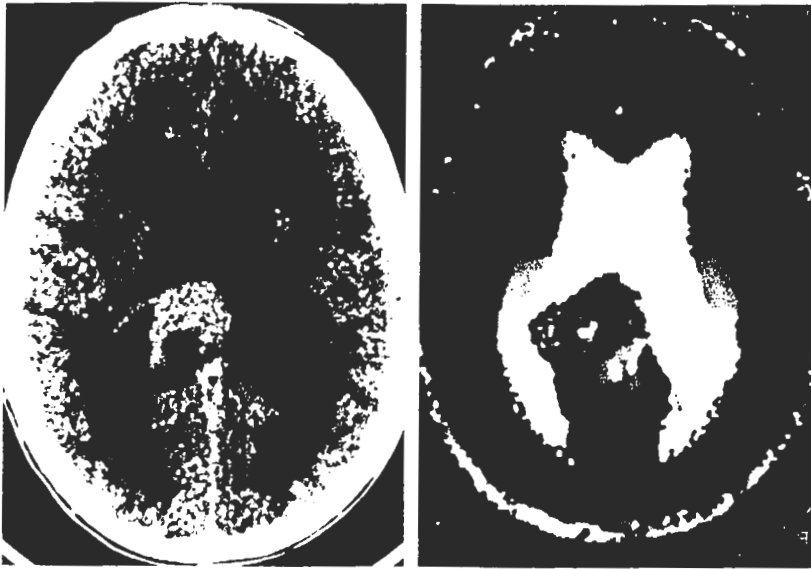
Extraventricular thalamic astrocytoma in a 7½-year-old boy. a: Intravenously enhanced axial CT scan. b: Superior view of 3D CT. The exophytic thalamic mass compresses the inferomedial portion of the atrium and deforms the cistern of the vein of Galen.
